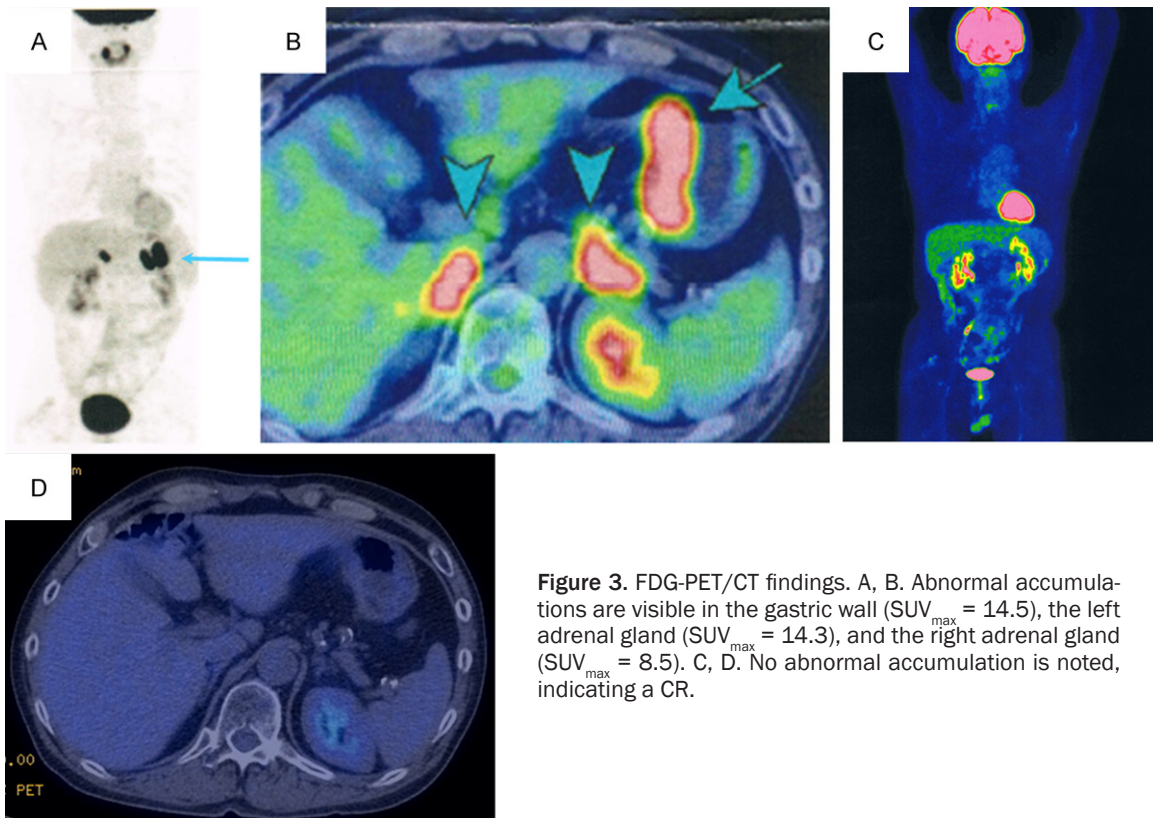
FDG-PET/CT findings. A, B. Abnormal accumulations are visible in the gastric wall ($SUV_{max} = 14.5$), the left adrenal gland ($SUV_{max} = 14.3$), and the right adrenal gland ($SUV_{max} = 8.5$). C, D. No abnormal accumulation is noted, indicating a CR.
